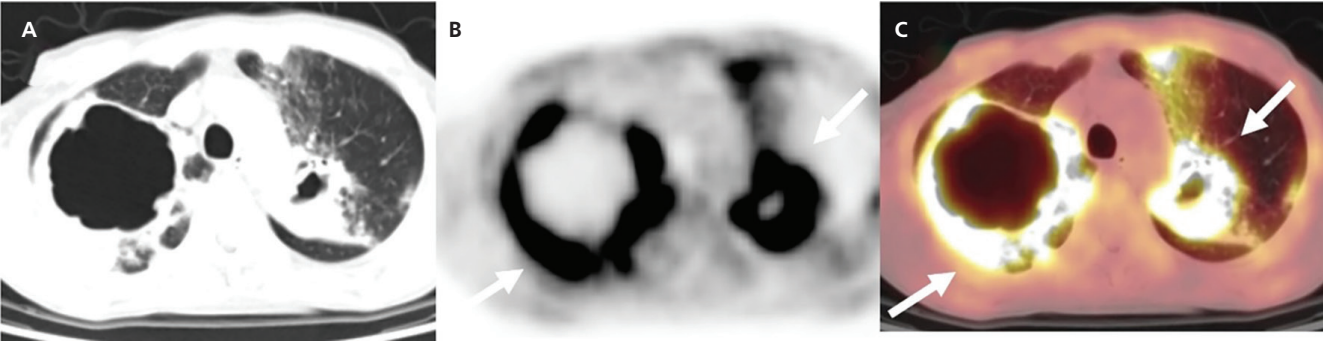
Tuberculosis. Axial CT (A), ¹⁸F-FDG PET (B), and fusion PET/CT (C) images show irregular, thick-walled cavitory lesions surrounded by infiltrated pulmonary parenchyma in both lungs, with the largest lesion located in the right apical region measuring approximately 85 mm (arrows). Increased metabolic activity is observed along the cavity walls (SUV_{max}: 14.34)
